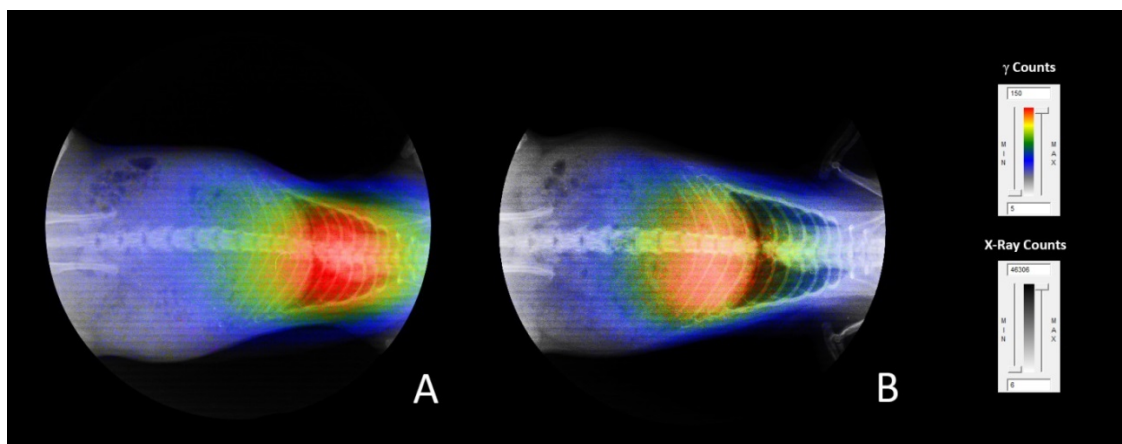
Un-collimated, non-decay-corrected full body X-Ray/Autoradiography of A: ^{99m}Tc -PGCD compared to B: free ^{99m}Tc after 10 minutes.
